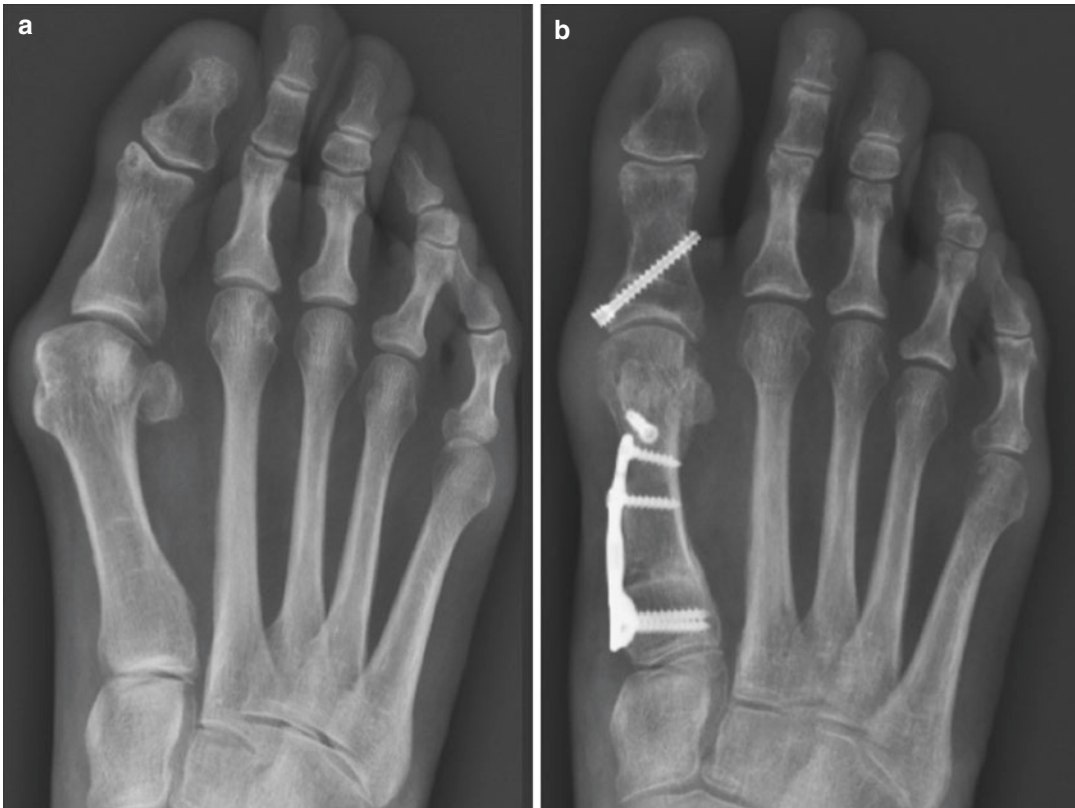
A hallux valgus deformity on weight bearing radiographs (a). The same patient 6 months following a combination of basal metatarsal osteotomy, chevron osteotomy and Akin osteotomy (b)
